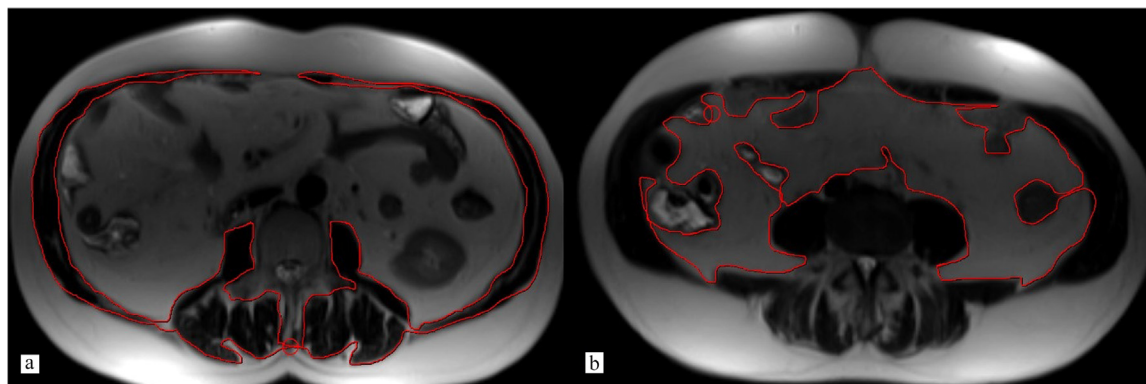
Abdominal MR images of a cirrhotic female patient with sarcopenic obesity. Total skeletal muscle area and visceral adipose tissue area calculated by free manual tracing method. Skeletal muscle area 87 cm^2 , height 1.68 m^2 , skeletal muscle index $30.8 \text{ cm}^2/\text{m}^2$, visceral adipose tissue 160 cm^2 .
